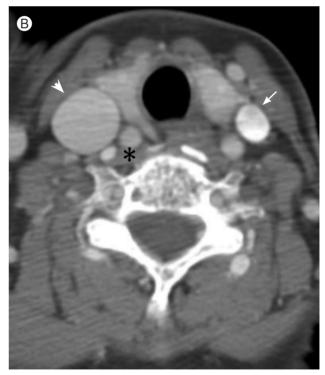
Computed tomographic angiography. The left internal jugular vein (arrow) was not enhanced during arterial phase, compared to enhanced right internal jugular vein (arrowhead) (A). The delayed left internal jugular vein (arrow) was observed during late venous phase (B) (\* carotid artery).
